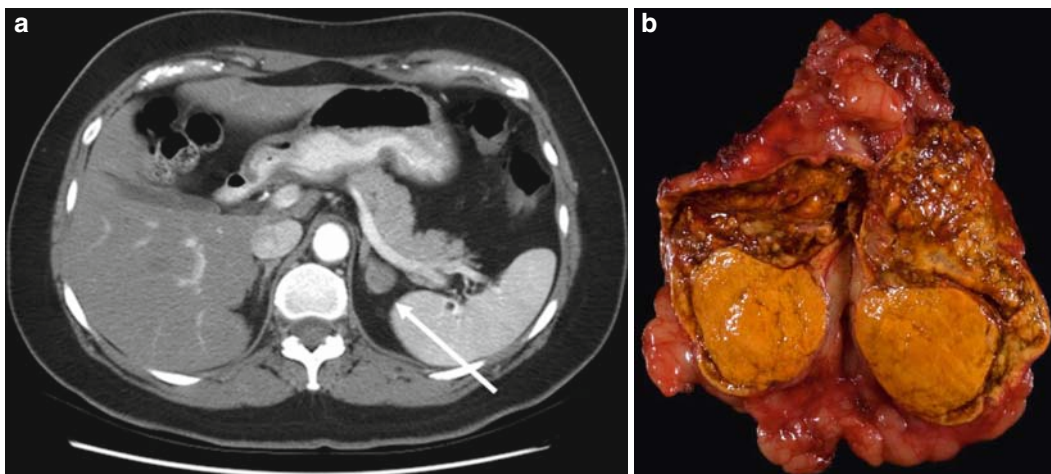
(a) CT with intravenous contrast of a left-sided aldosteronoma denoted by *arrow* (b) corresponding pathology.
